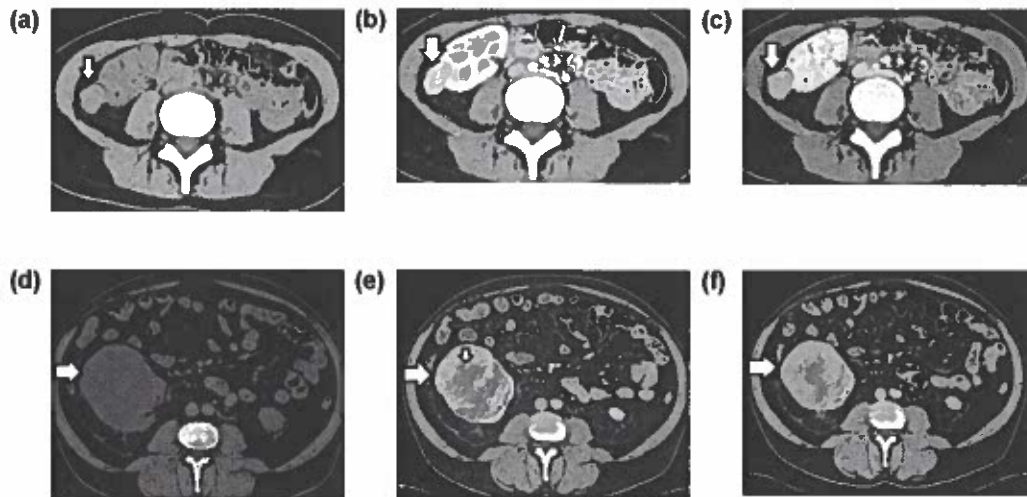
CT findings of common benign solid renal tumors. Fat-poor AML. Transverse (a) non-enhanced and contrast-enhanced CT images during the (b) corticomedullary and the (c) nephrographic phase depict a small, mainly exophytic right renal mass (arrow). The tumor appears hyperdense on unenhanced images (45 HU), when compared to normal renal parenchyma, with early, marked contrast enhancement, followed by rapid deenhancement. Renal oncocytoma. Transverse (a) non-enhanced and contrast-enhanced CT images during the (b) corticomedullary and the (c) nephrographic phase show a large, well-defined right renal mass (arrow). The tumor is detected heterogeneous, mainly hypodense on unenhanced images. After intravenous contrast medium administration, it reveals an avid, early peripheral enhancement (arrow), followed by moderate washout (arrow) and a large, central non-enhancing stellate scar (small arrow, b).
